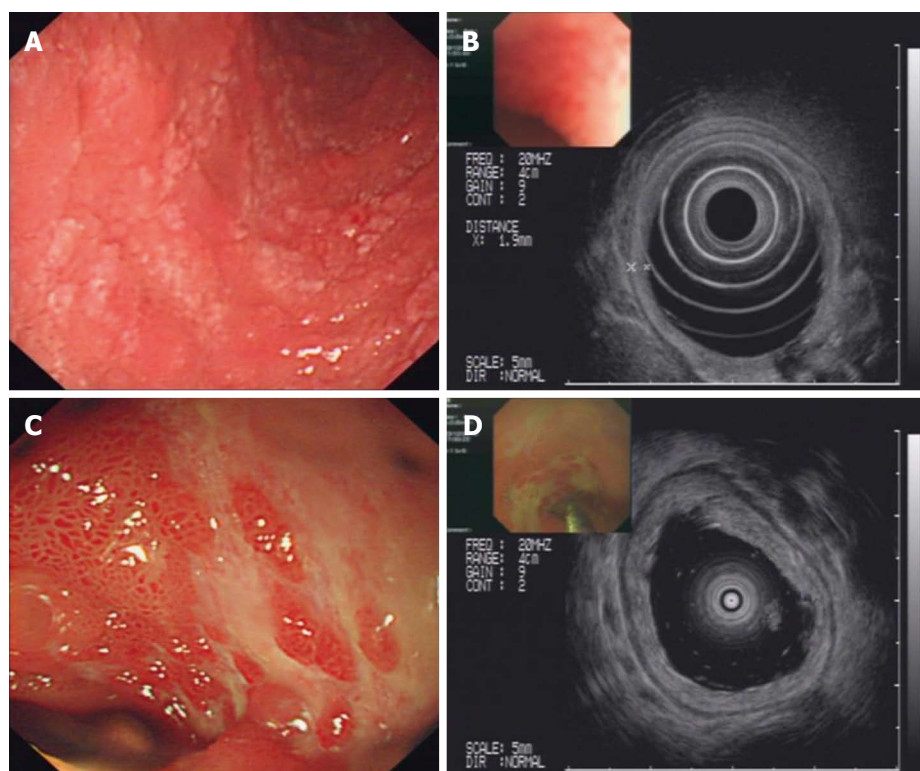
The extent of damage to the intestinal mucosa improved after treatment. A: Gastroscopic image of the duodenum; B: Ultrasound endoscopy (EUS) image of the duodenum; C: Colonoscopic image of the terminal ileum; D: EUS image of the terminal ileum.
